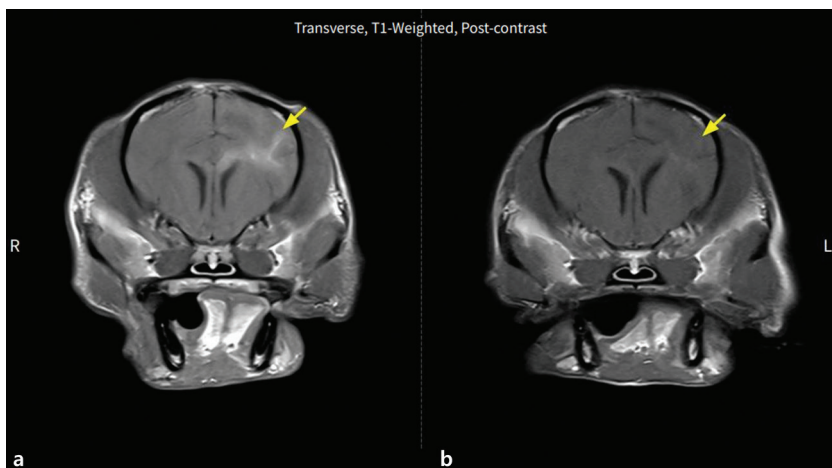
Sequential T2-weighted MR images of the left frontal lobe
